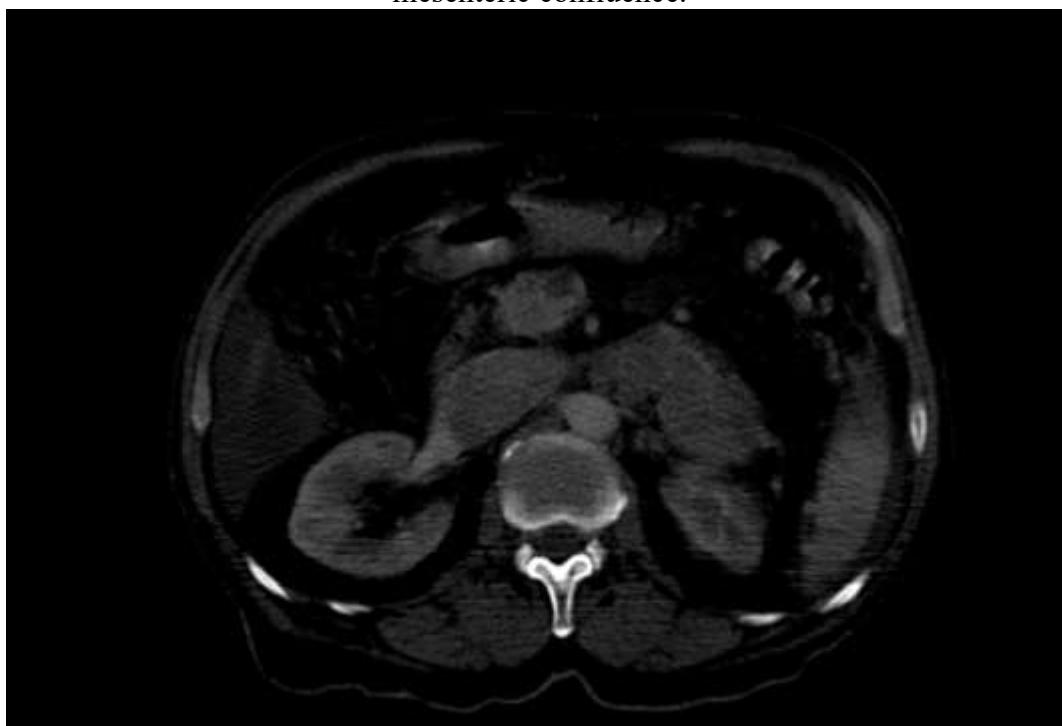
Axial contrast-enhanced CT image demonstrating extension of tumor thrombus into the superior mesenteric vein and splenic venous axis.
